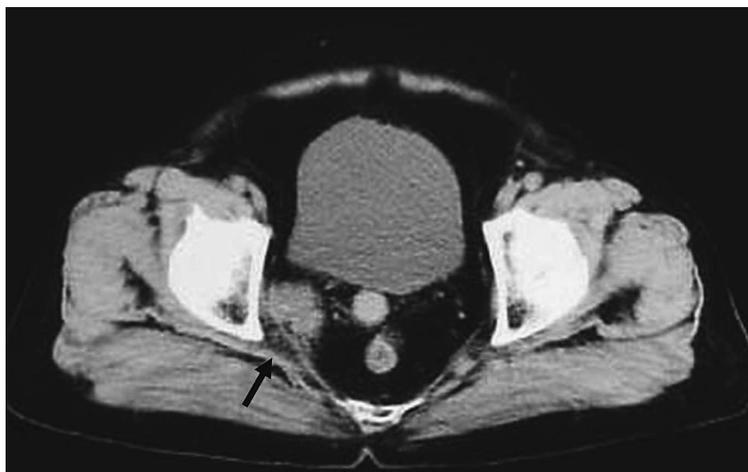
Computed tomography shows the metastatic lesion in the right obturator lymph node (arrow).
